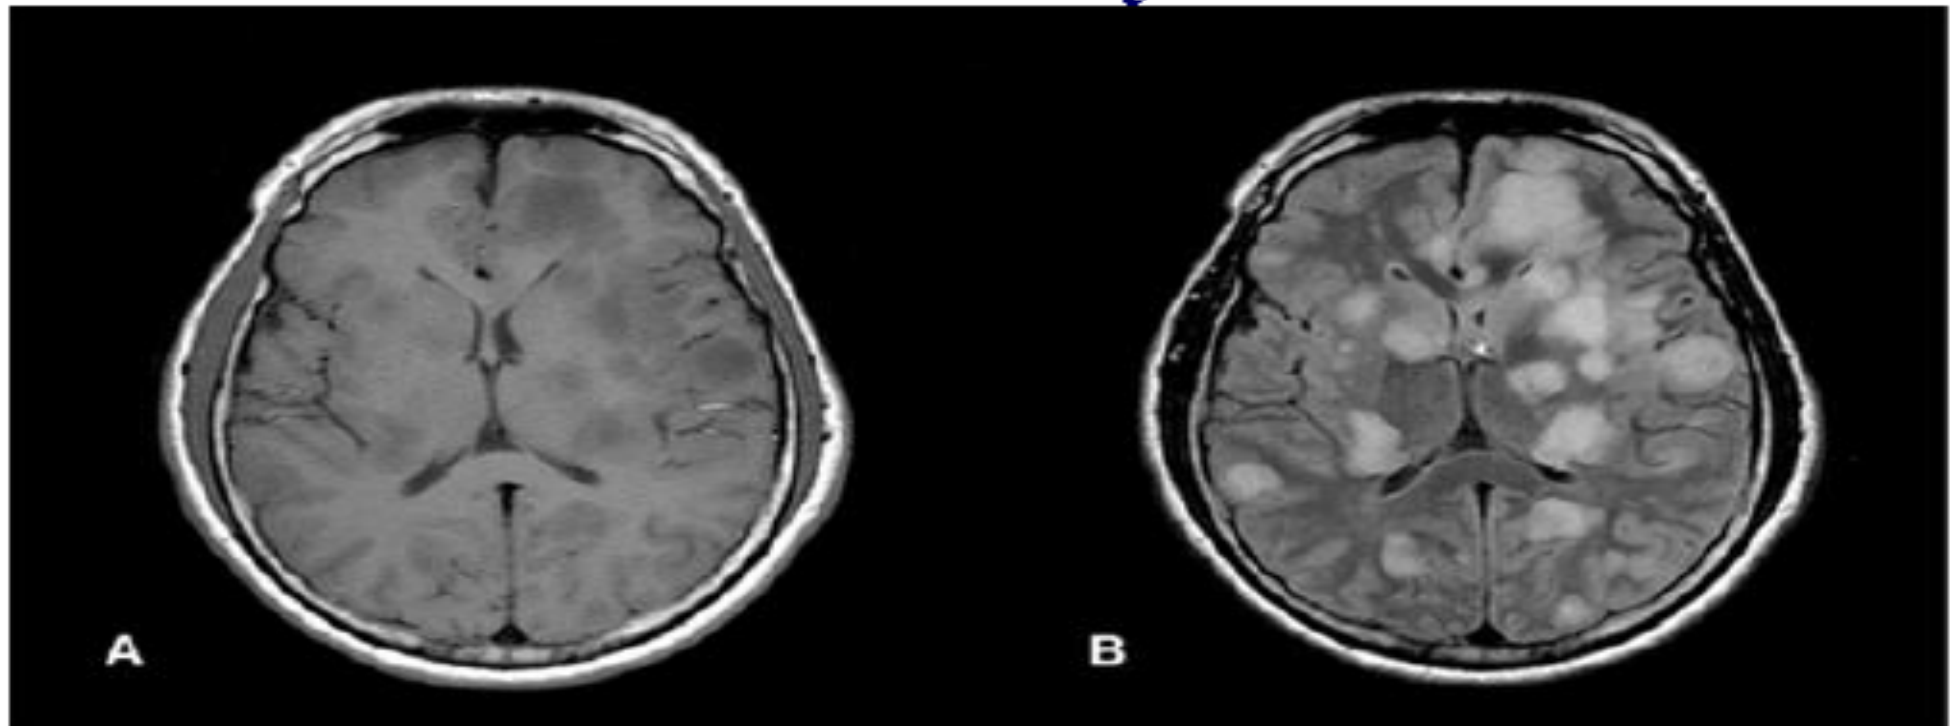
Axial T1-weighted brain magnetic resonance imaging discloses multiple irregular hypointense lesions (A) without mass effect, which are better individualized in the FLAIR sequence (B).
